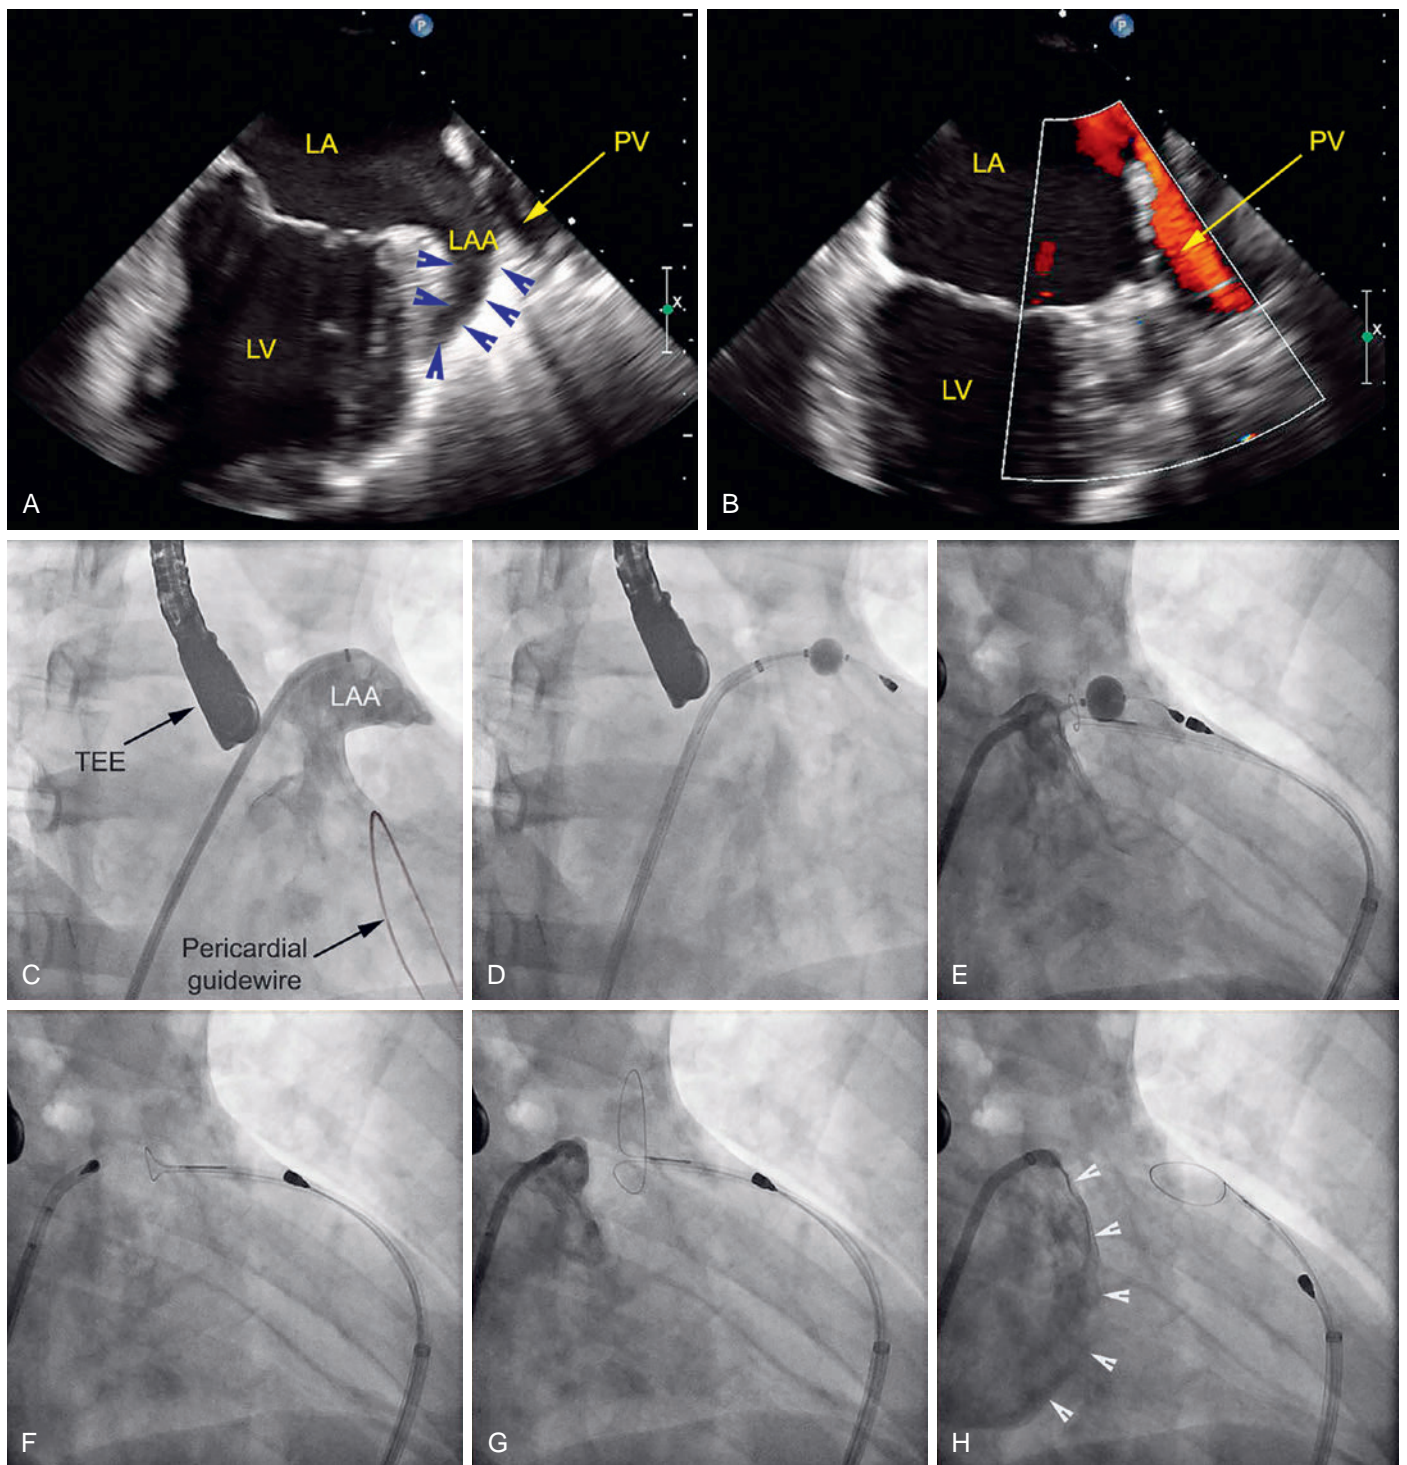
Percutaneous Left Atrial Appendage (LAA) Ligation Using the Lariat Device. Transesophageal echocardiography (TEE, A and B) and fluoroscopic images (C–H, caudal right anterior oblique projections) during Lariat ligation of the LAA. (A) TEE at baseline showing the LAA. (B) TEE Doppler image after LAA ligation showing obliteration of the LAA, with no flow jet in the LAA. Flow can be seen in the left superior pulmonary vein (PV) adjacent to the LAA. (C) After obtaining pericardial access (pericardial guidewire is visualized), left atrial (LA) access is obtained via a transseptal atrial puncture. The transseptal sheath and a pigtail catheter are positioned within the LAA. Contrast angiography of the LAA is performed to delineate LAA anatomy. (D) The endocardial magnet-tipped guidewire is placed in the most anterosuperior aspect of the LAA. The balloon is inflated and positioned just distal to the ostium of the LAA. (E) The epicardial magnet-tipped guide wire is advanced via the pericardial sheath and navigated toward the endocardial magnet-tipped guidewire until both magnets connect end to end. Then, the Lariat is guided along the epicardial guidewire, and the snare is tightened around the base of LAA. Exclusion of the LAA by the closed snare is confirmed by angiography (via the transseptal sheath). (F) The occlusion balloon is deflated and the magnet-tipped guidewires are disconnected. The preloaded, pretied suture is then released from the snare and tightened. (G) LAA closure is verified again with angiography. (H) The Lariat device is then pulled back off the LAA. Contrast angiography (via the transseptal sheath) of the LA (arrowhead delineate the LA border outlined by the contrast dye) confirms complete exclusion of the LAA. LV, Left ventricle.
